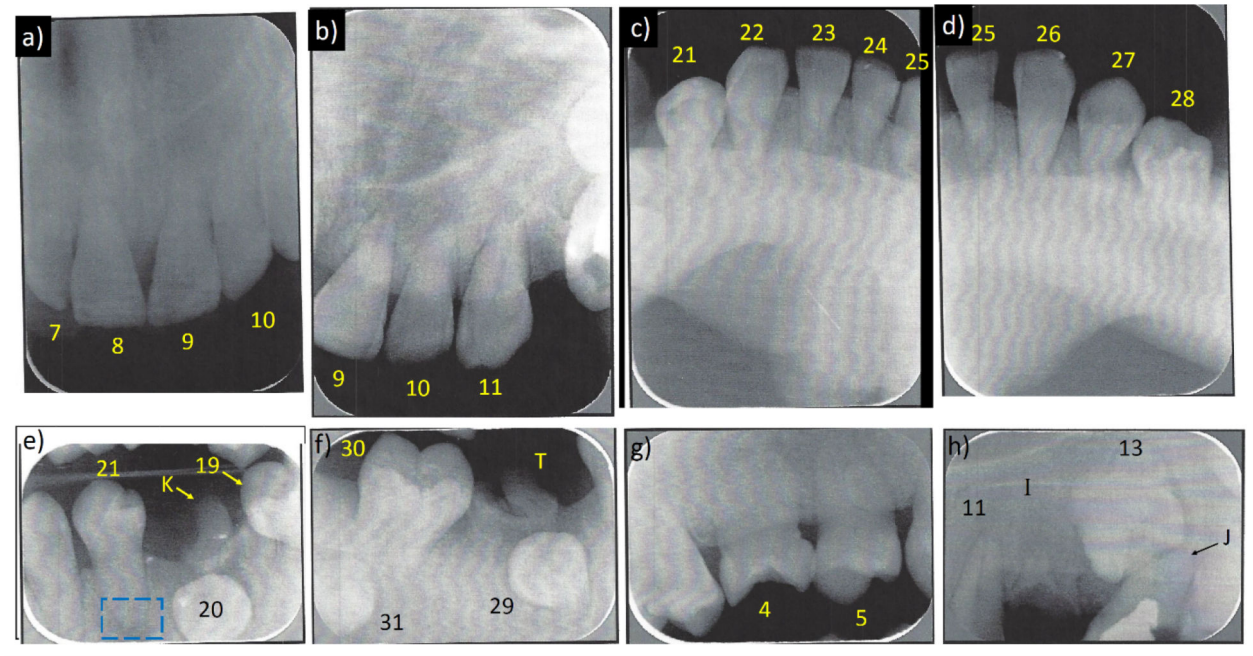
Patient's Dental Radiography At Age 15 Years
